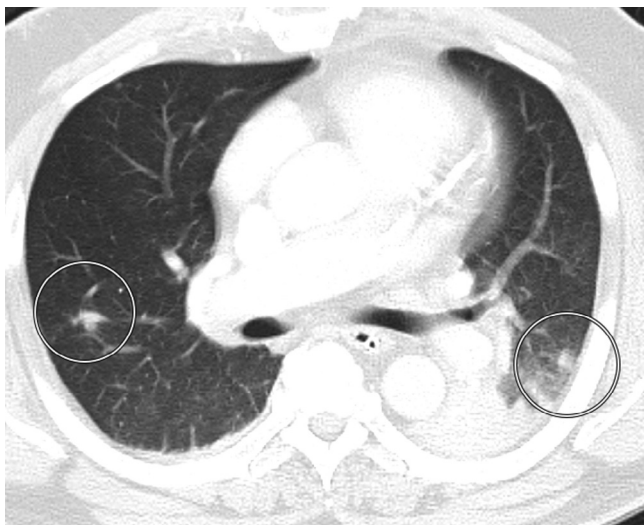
Representative computed tomography image in lung windows showing small bilateral pulmonary nodules. There is adjacent consolidation in the left lower lobe.
